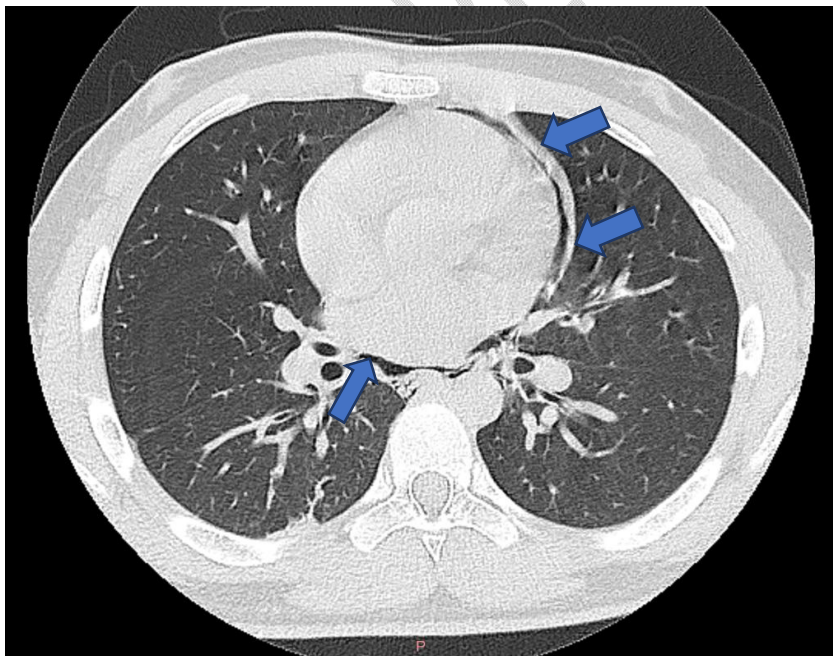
HRCT Thorax revealing pneumomediastinum
